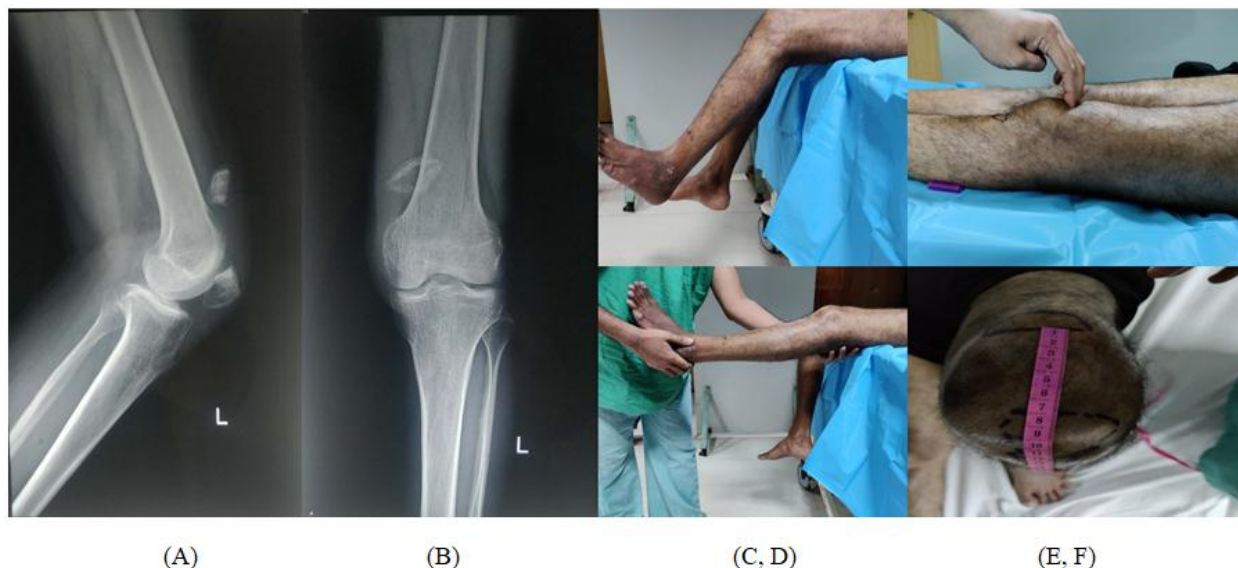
A, B): Pre-operative plain antero-posterior and lateral radiographs suggestive of displaced patellar fractures with superior migration of proximal pole (C, D): Left knee extensor lag of 45 degree which is passively correctable to 5 degrees of extension, (E,F): Palpable patellar gap between two fragments, A gap of 7cm between two fragments seen on knee flexion)
